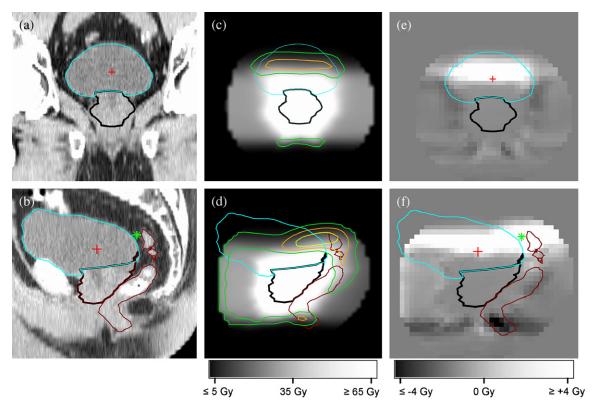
(a, b) Coronal and sagittal views of computed tomography scan in prostate/bladder region for template patient (blue, bladder; black, prostate; dark red, rectum). Cross indicates trigone point 2 cm above starting point of prostatic urethra in coronal slice with urethra visible. Asterisk in Fig. b indicates region in which largest dose differences were found (see Fig. 1e, f). (c, d) Average planned dose for all patients in corresponding coronal and sagittal views. Apart from delineated organs, contours of standard deviations included to indicate roughly area of largest dose variations (green, 10-Gy contour; orange, 15 Gy; yellow, 20 Gy). (e, f) Dose difference maps (coronal and sagittal views). Mean dose map of patients without urinary obstruction subtracted from mean dose map of patients with obstruction. White region indicates significant (p < .02) dose differences (range 4–12 Gy). Asterisk in Fig. f indicates region with largest dose differences.
